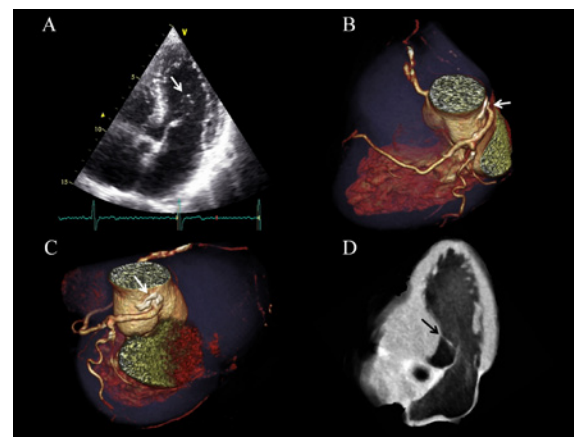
(A) Two-dimensional echocardiography: apical four-chamber view showing accessory mitral valve tissue (white arrow) connected to the anterior leaflet, floating in the ventricular cavity in diastole. (B-C) Cardiac computed tomography (cCT)-3D reconstruction- presenting the anomalous origin of the LCA (white arrow) and the huge atherosclerotic plaque extending from the aorta in the LM (white arrow). (D) 3D reconstruction from cCT: anatomical section showing the accessory mitral valve tissue in diastole (black arrow).
